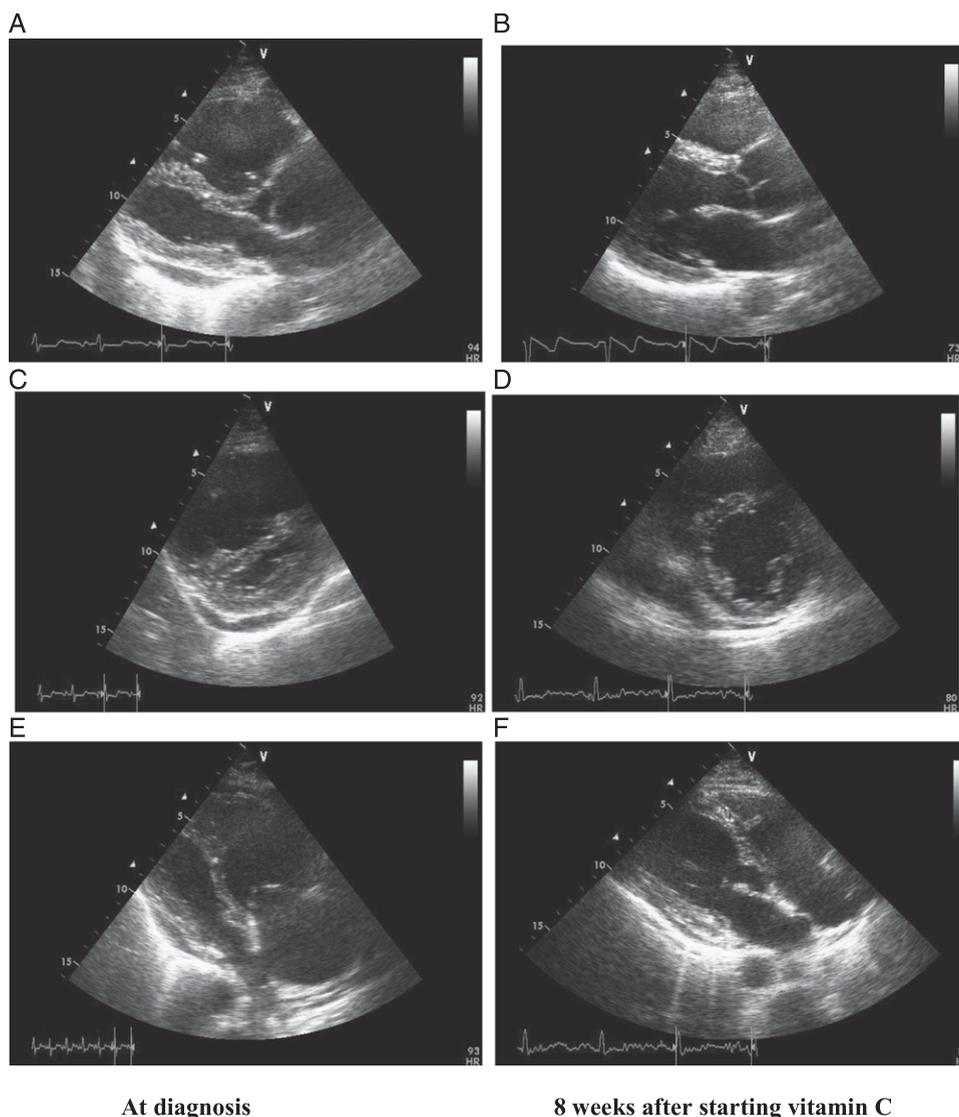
Diastolic images of the heart at diagnosis of pulmonary hypertension (left) and during vitamin C supplementation (right). A and B, Long axis. C and D, Short axis. E and F, Apical four-chamber planes. Note the dilated right side of the heart and the severely flattened left ventricle before treatment and the full normalization of findings after vitamin C supplementation. HR = heart rate.
